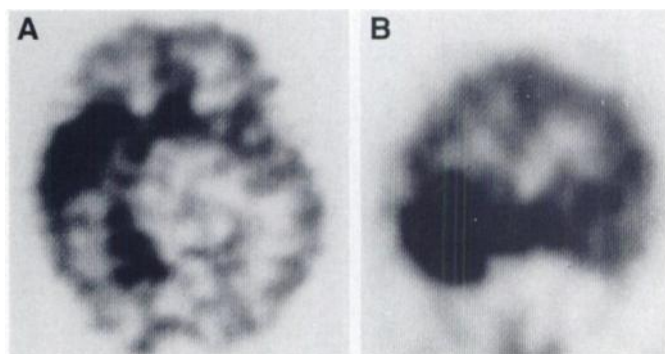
SPECT images of Patient 2. Axial slices parallel to and 24 mm above the canthomeatal line (A) and coronal slices (B) are shown. Note increased uptake of ^{99m}Tc-HMPAO in right temporal lobe.
